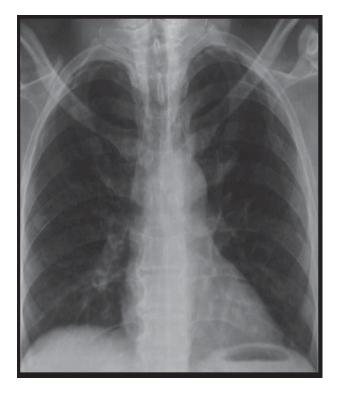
Chest X-ray, CT scan of Vertebra and skull X-ray didn't show any lesion suggestive of systemic pathology.
